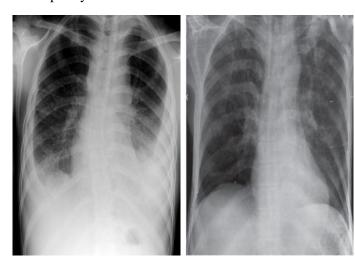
X-ray report of TB patient before and after treatment
